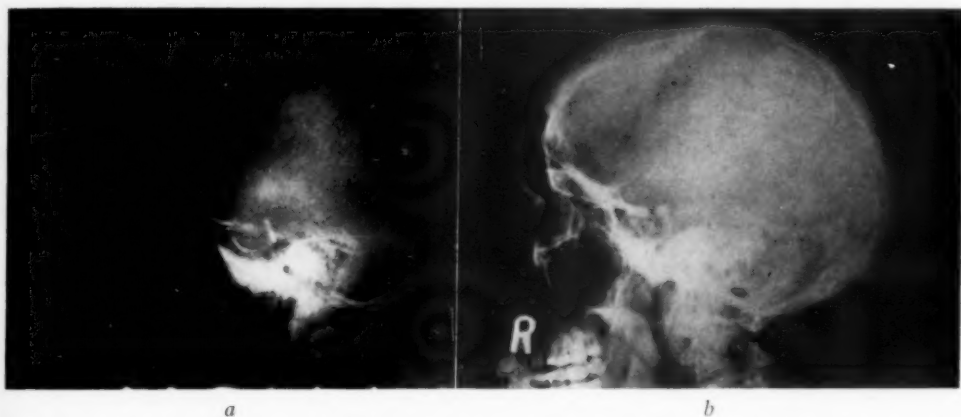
a*. Roentgenogram, 1928, showing marked enlargement of the sella turcica and hypertrophy of the posterior clinoid processes. *b*. Roentgenogram, 1938, showing no significant change from the 1928 film.
